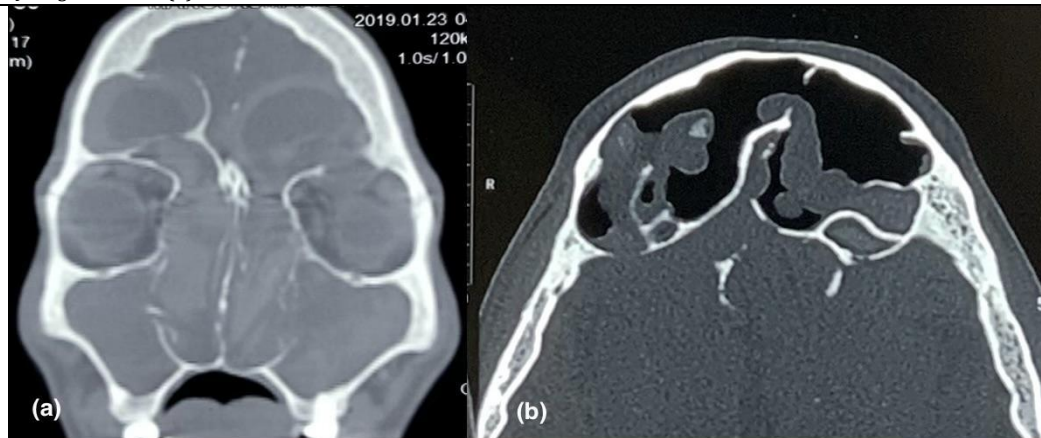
Computed tomography of paranasal sinuses (CT-PNS) coronal section showing extensive bilateral sinonasal polyposis (a) with abnormally large frontal sinus bulging into intracranial compartment. Axial view of CT-PNS in the same patient showing absent interfrontal septum, large frontal sinus & polyps (b).
